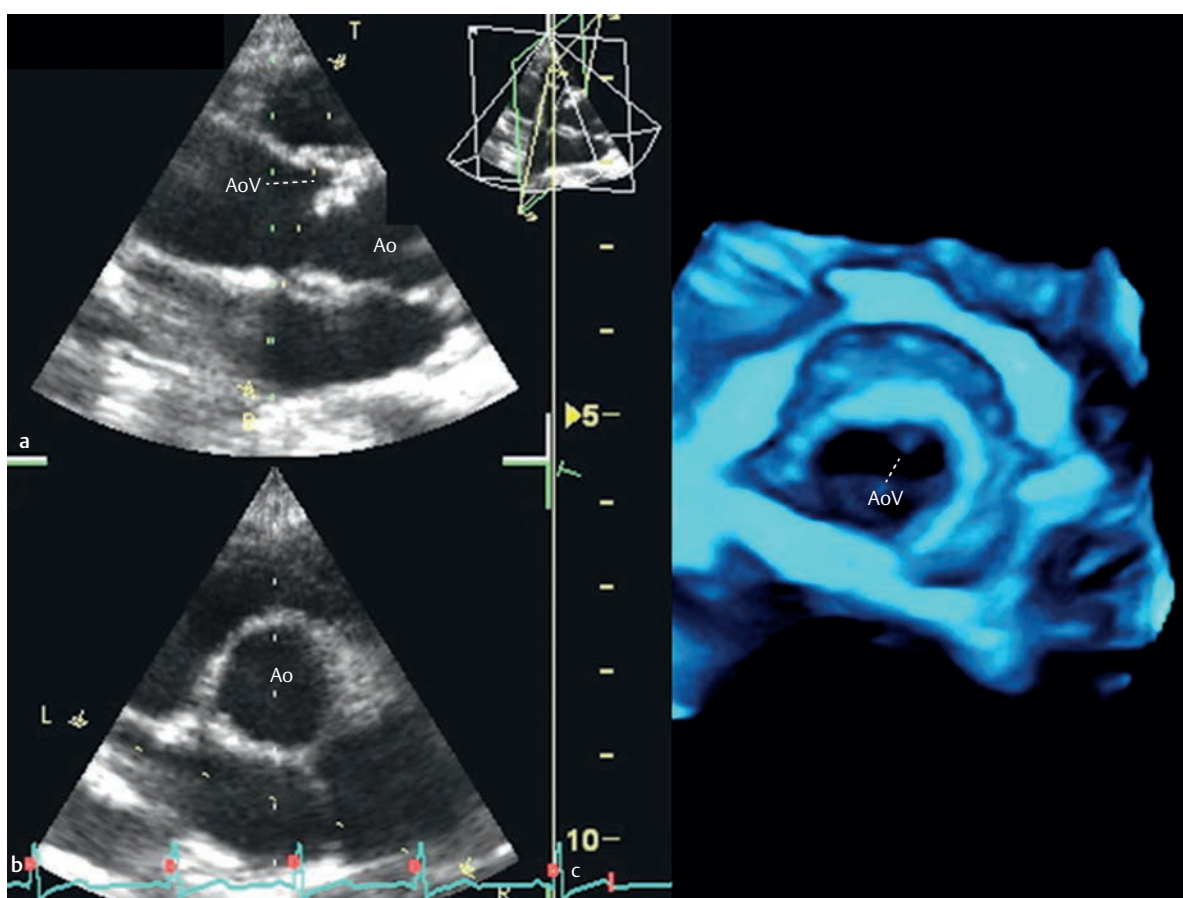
3-D echocardiography.
